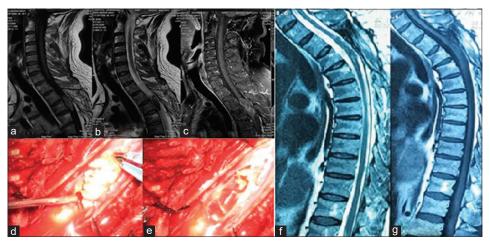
(a) Cervicothoracic T1-weighted magnetic resonance imaging (MRI) the tumor is isointense, (b) in T2-weighted mage it is hypointense which is unusual for intramedullary epidermoid cysts, (c) but in fat-suppressed MRI the hyperintense mass is compatible with epidermoid, (d) intraoperative photograph shows the characteristic features of and epidermoid cyst, (e) after total removal, (f) T1-weighted MRI at 10-year follow-up shows neither residue nor recurrence, (g) T2-weighted image also is clear.
